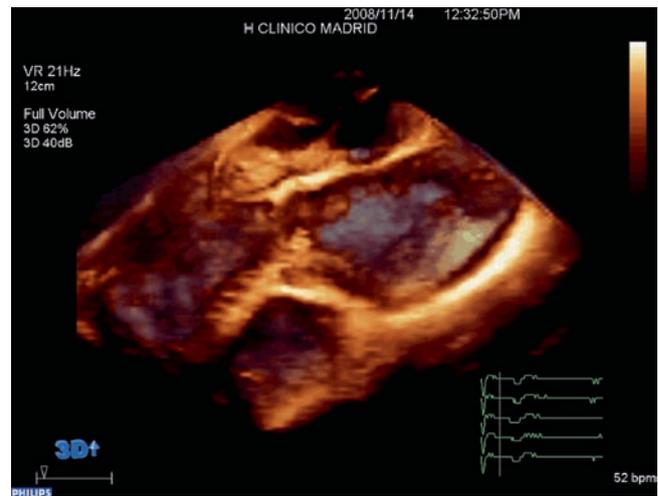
Real-time 3D trans-oesophageal echocardiography (TOE) may help in some circumstances to evaluate the morphologic characteristics of aortic aneurysms
